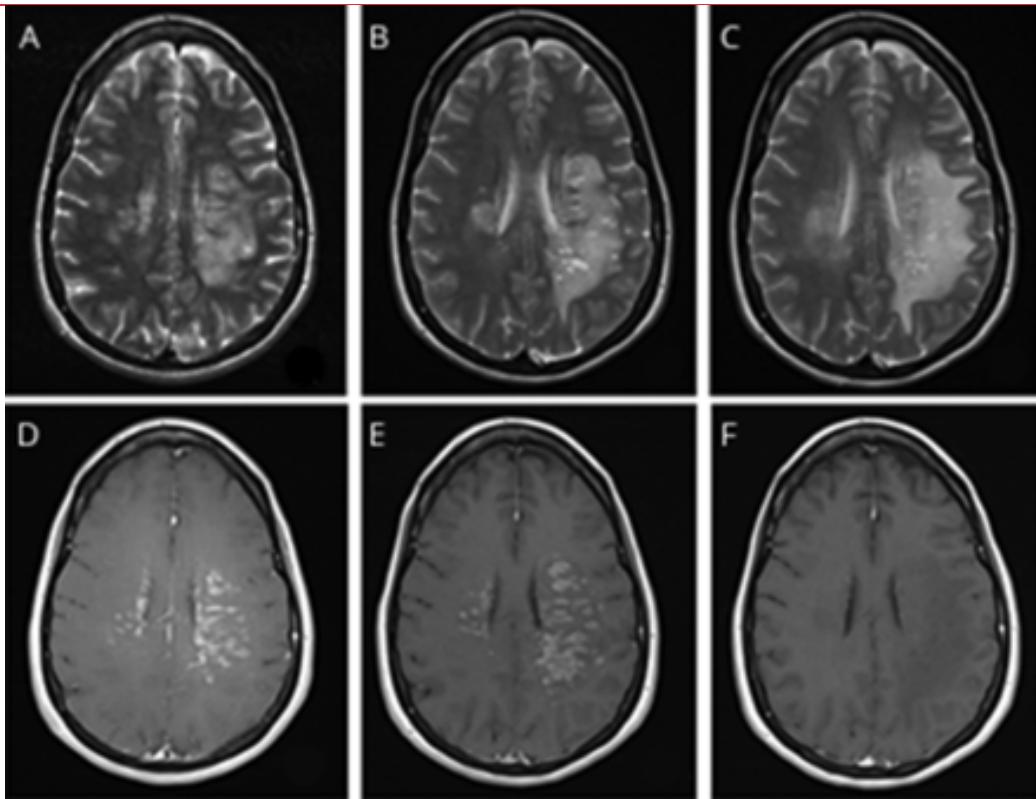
MRI appearances of CNS inflammatory vasculopathy with antimyelin oligodendrocyte glycoprotein antibodies in COVID-19. T2-weighted axial images at day 1 (A), day 6 (B), and post-treatment day 17 (C). Postcontrast axial images at day 1 (D), day 6 (E), and post-treatment day 17 (F).
